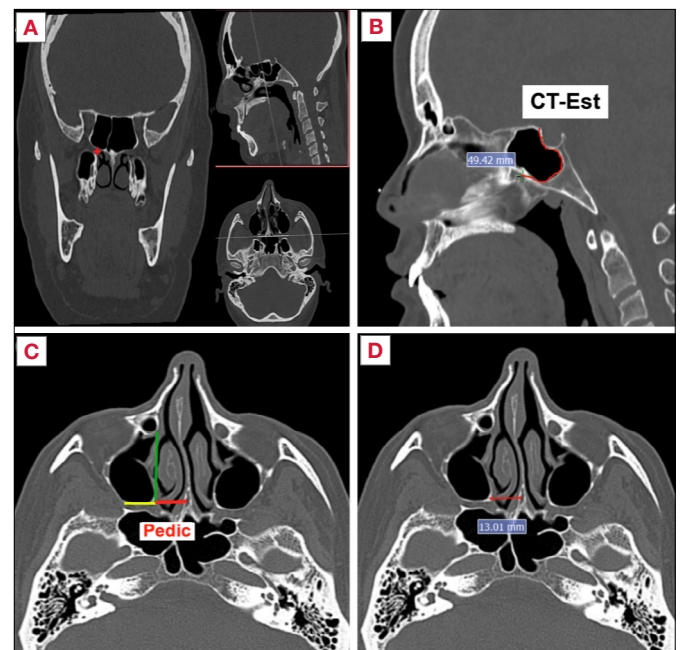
A) Identification and annotation of the sphenopalatine foramen (red cross) in a coronal CT slice and visualisation of its projection in axial and sagittal slices; B) CT-Est: measurement of the projection of the sphenopalatine foramen (green cross) to the tuberculum sellae in a midline sagittal slice; C) Pedic: 2 perpendicular lines are drawn, one parallel to the medial wall of the maxillary sinus (green) and the other to the posterior wall of the maxillary sinus (yellow); D) The distance between the intersection of these lines and the nasal septum corresponds to the length of the flap pedicle.
